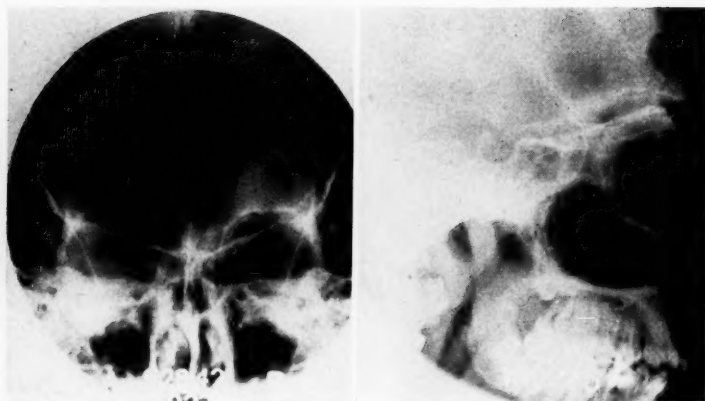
Roentgenograms showing excision of frontal sinuses and frontal bone for osteomyelitis.
